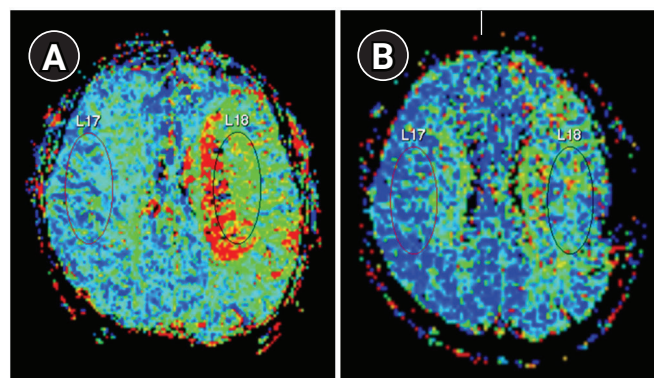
Perfusion weighted magnetic resonance imaging (PWI) of case 3. Preoperative PWI showed prolonged mean transit time (MTT) (A). As can be seen, PWI at 1 week after surgery showed that MTT decreased following STA-MCA bypass (B). Region of interest was positioned at the centrum semiovale level.
